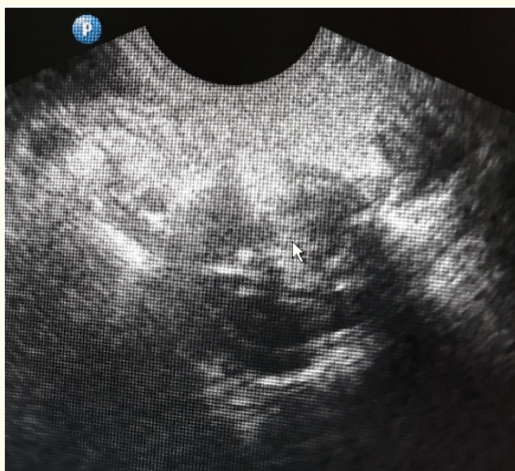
Ultrasonogram of the intervertebral disc in the axial section. Arrow shows macrofocal heterogeneity of disc.
